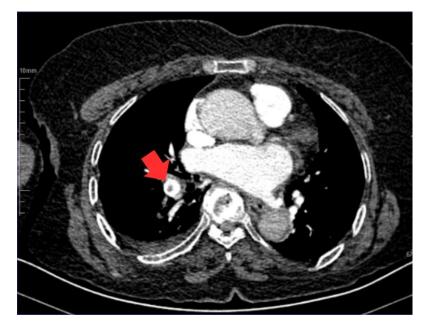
Red arrow - Filling defect (thrombus) observed in the distal left pulmonary artery in the acquired CT angiography (CTA).
